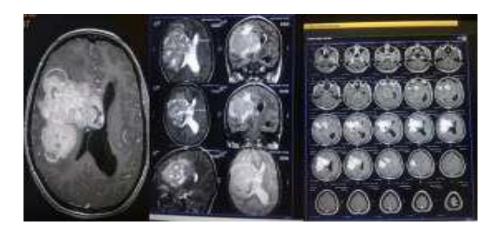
Preoperative MRI Brain
